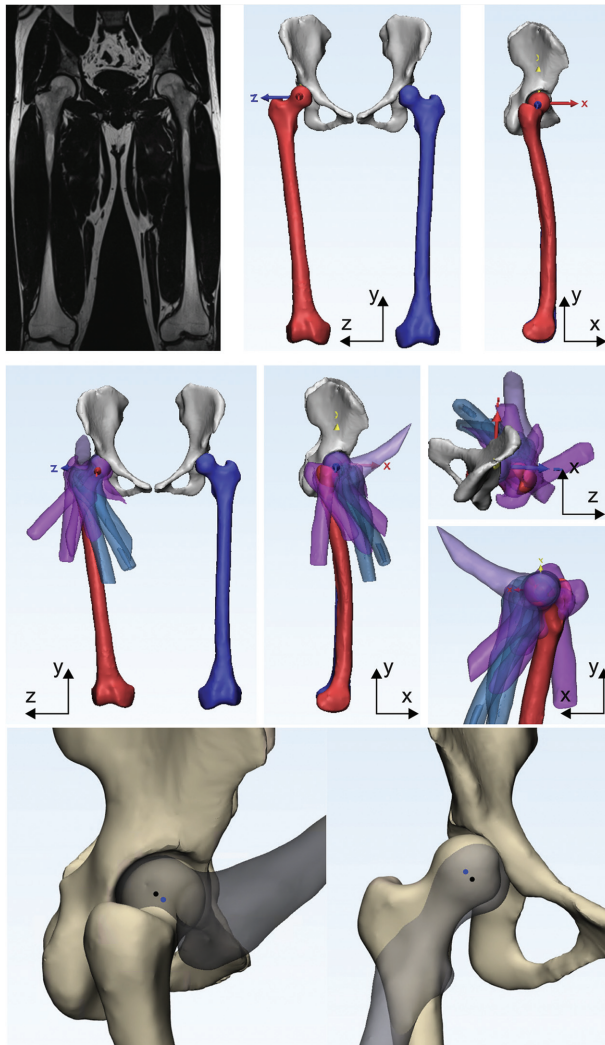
Top row, Development of 3-D models from MRI scans and definition of anatomic coordinate system (+x, anterior; +y, superior; +z, lateral). Middle row, Model registration to calculate the relative rotation and translation of the femur with respect to the neutral position. The transparent femora are segmented femora from all different positions, which have been registered to the neutral position by matching the pelvis models. The registered and superimposed 3-D femur models were then used to calculate the femoral rotation and translation in the same coordinate system as the neutral models. Bottom row, Hip translation was measured as the distance of between the femoral head center during rotations (black) and femoral head center in the neutral position (blue). 3-D, 3-dimensional; MRI, magnetic resonance imaging.
